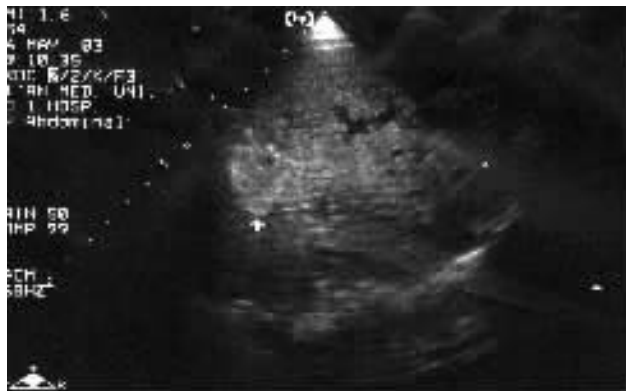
Ultrasound shows a 33 mm x 16 mm signal intensity lumen of identical echo in the confluence of the right and left hepatic ducts in continuity proximal common bile duct, with dilatation of both intrahepatic bile ducts
